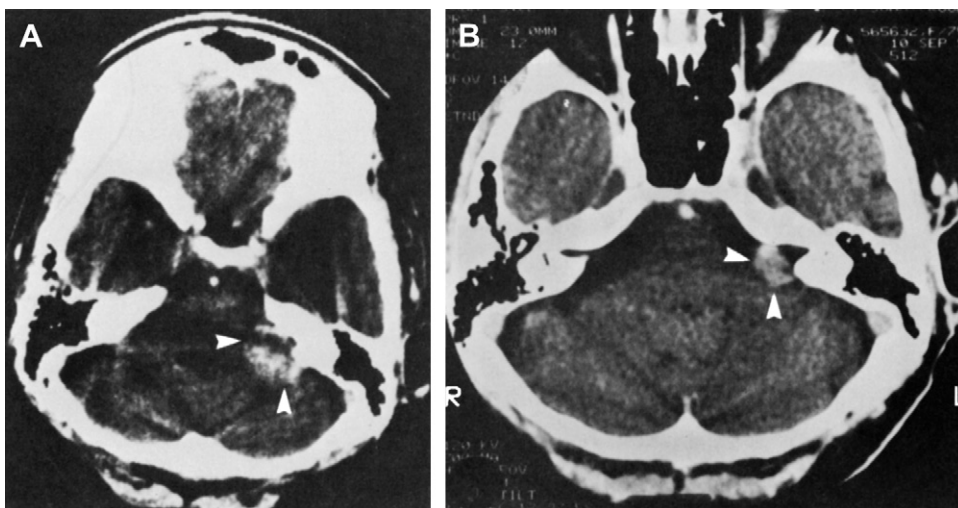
Enhanced axial computed tomography images. Tumor demonstrating reduction in size over 7 years of follow-up. (A) Tumor measures 2.2 cm in May, 1984; (B) tumor measures 1.05 cm in September, 1991.
